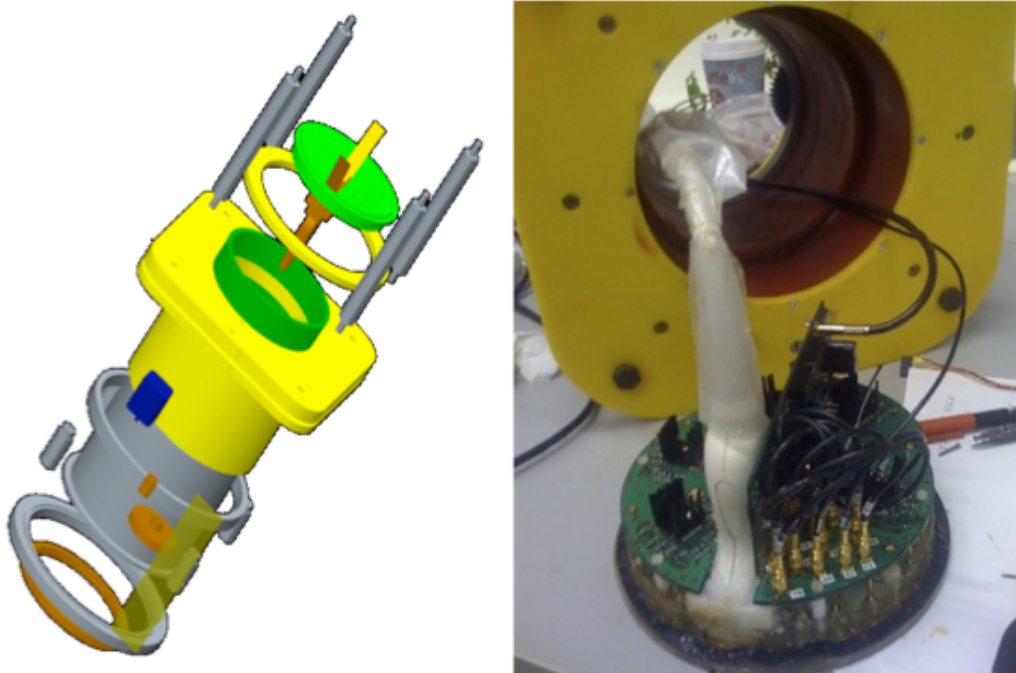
Exploded CAD assembly of V3b scanner (left); Disassembled V3b showing electronics and ultrasound (right).
